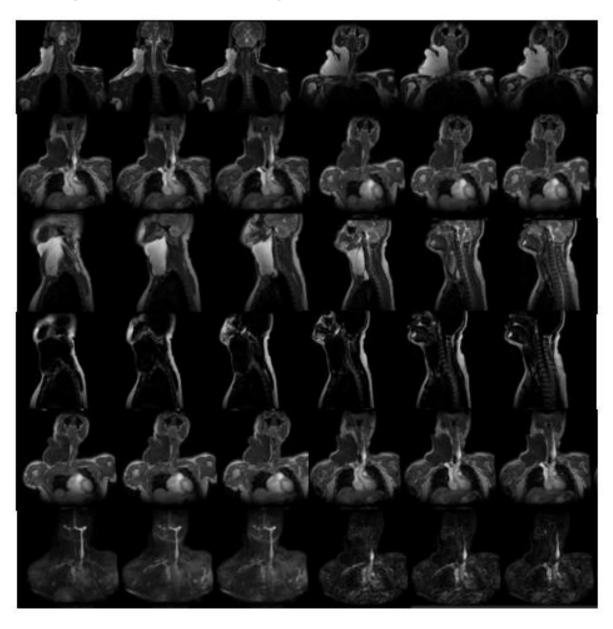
Cervical MRI with contrast
